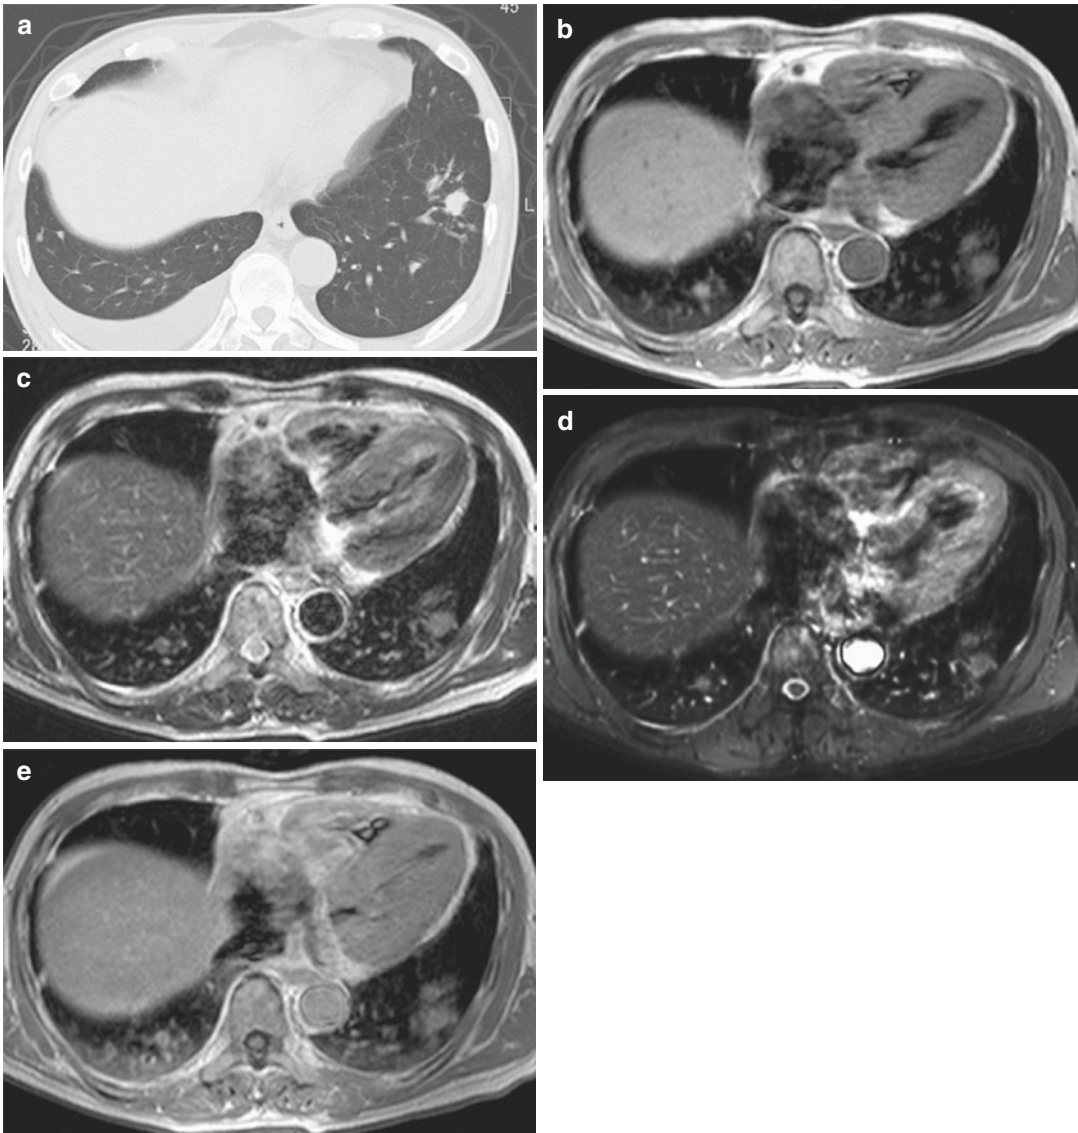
A 55-year-old male with cryptococcosis in the left lower lobe. Thin-section CT shows a solid nodule in the left lower lobe (a). Black-blood T1-weighted turbo SE (b), T2-weighted turbo SE (c), and STIR turbo SE (d)
